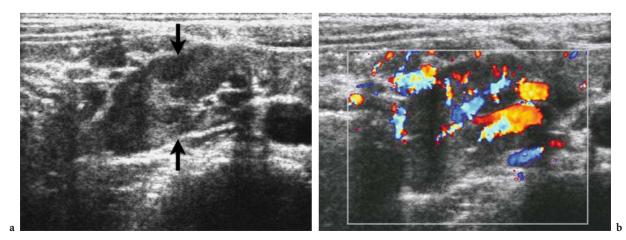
Mesenteric lymphadenitis. a US image shows enlarged mesenteric lymph nodes in the region to right of the umbilicus (*arrows*). b Color Doppler image shows increased flow reflecting hyperemia. Appendix was normal
